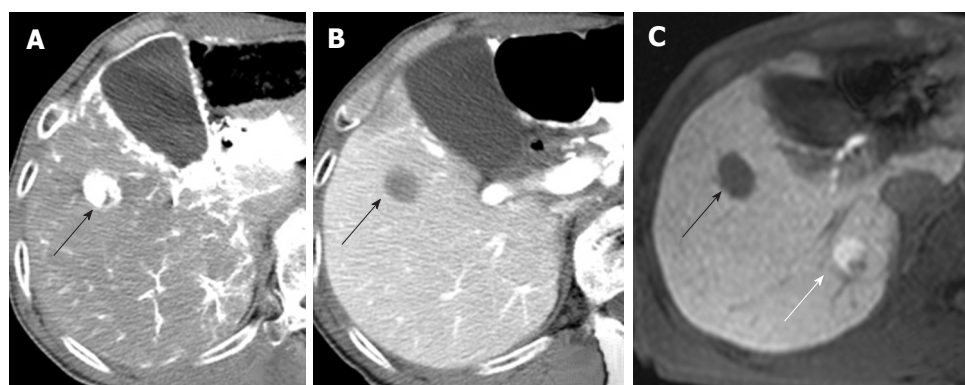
An 80-year-old man with poorly differentiated (black arrow) and well differentiated hepatocellular carcinoma (white arrow). A: Poorly differentiated hepatocellular carcinoma shows hypervascularity on computed tomography (CT) hepatic arteriography; B: Hypodensity on CT during arterial portography; C: Hypointensity in hepatobiliary phase on gadoxetic acid-enhanced magnetic resonance imaging (MRI). The lesion is not visible on CT hepatic arteriography (A) or on CT during arterial portography (B) and shows hyperintensity in the hepatobiliary phase on gadoxetic acid-enhanced MRI.
